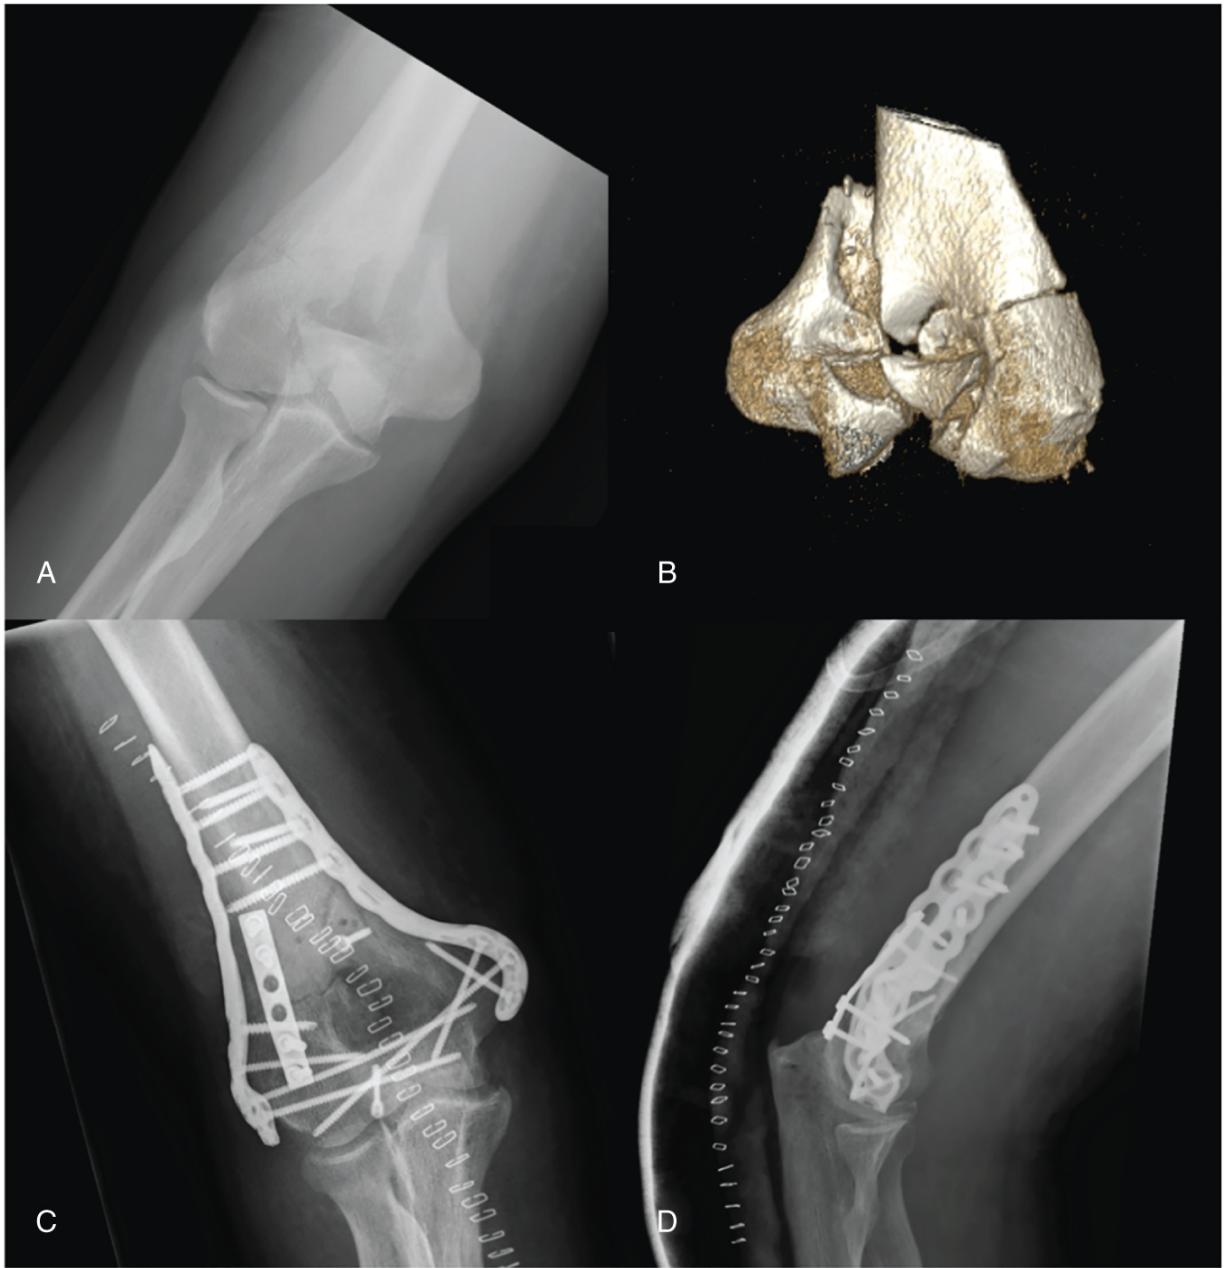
AP radiograph and 3D CT scan reconstruction of a 58-year-old male patient with a comminuted intra-articular distal humerus fracture (A and B). Postoperative radiographs following ORIF with parallel plating performed through a triceps-splitting approach (C and D).
